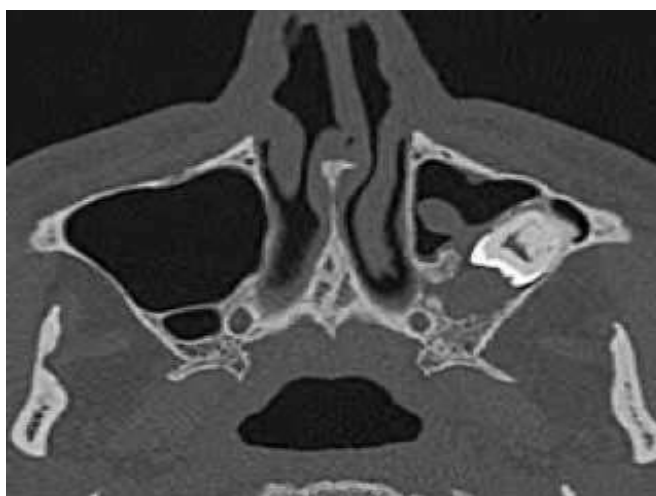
Computed tomography, odontogenic cyst on the left, nasomental projection.
